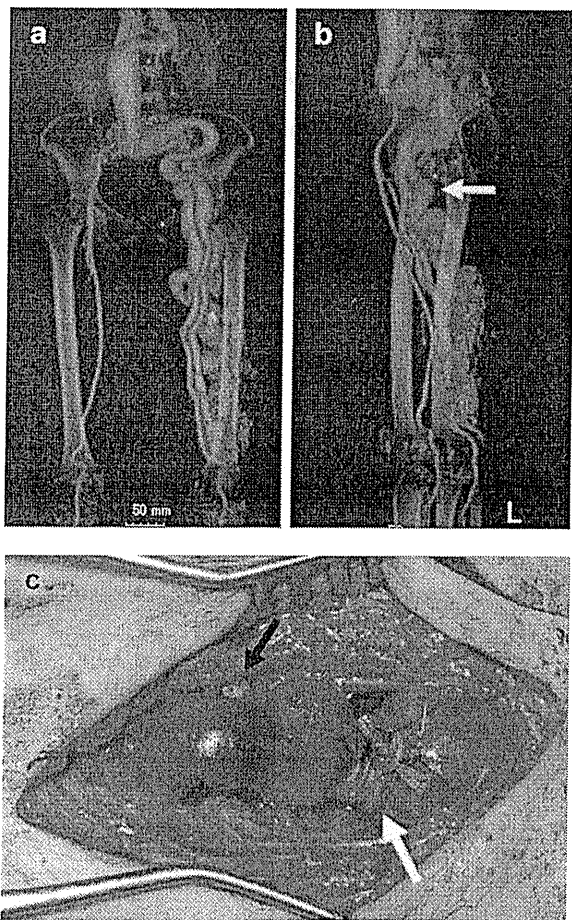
Patient 4. a,b, Preoperative computed tomography angiogram (a, frontal; b, from the left side). The congenital vascular malformation located at the left thigh was mainly fed through the aneurysm at the left deep femoral artery (DFA) (arrow). Aneurysmal dilatation was recognized at the abdominal aorta, left common iliac artery, left common femoral (CFA), and left DFA. c, Photograph after DFA cutoff (stump; black arrow) and CFA banding (white arrow). CFA banding was performed to monitor ankle pressure. After the banding, pulmonary arterial pressure and cardiac output decreased from 36 to 34 mmHg and 8 to 6 L/min, respectively.
